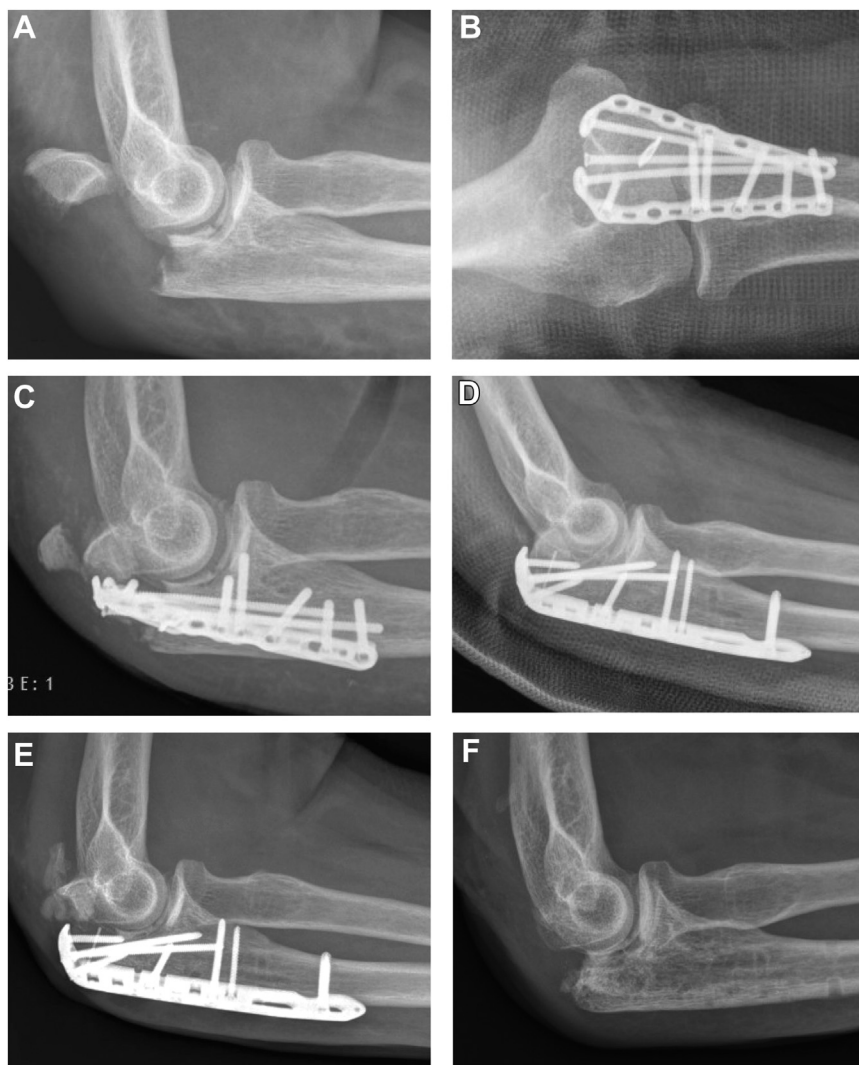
Radiographs of the right elbow of patient 1, (A) taken after the fall, (B) after double-plate osteosynthesis, (C) 6 weeks after surgery, (D) after revision surgery with a dorsal locking compression plate, (E) 2 weeks after revision surgery, and (F) 6 weeks after hardware removal and excision of the dislocated fragments.
